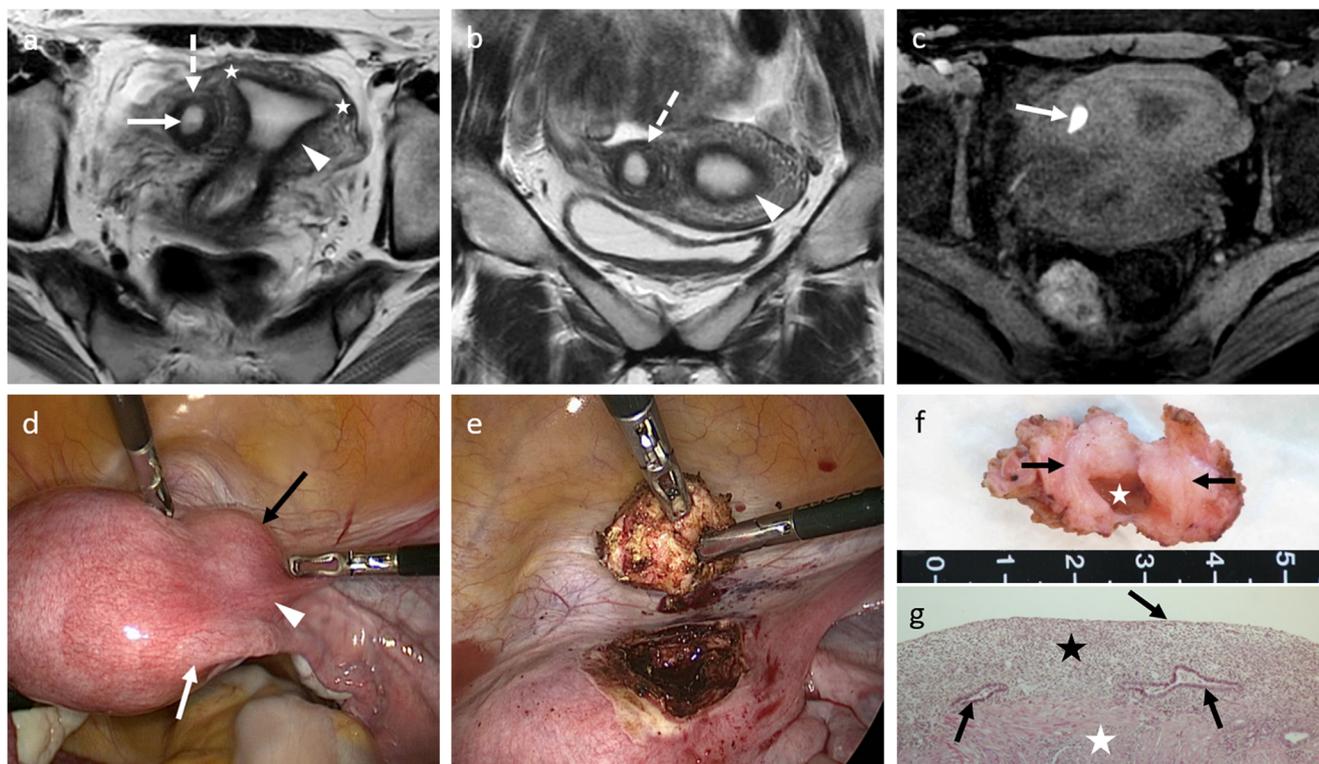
Case 4, a 22-year-old woman with catamenial gradually worsening right-sided pelvic pain. Axial (a) and coronal (b) T2-weighted MRI images show the presence of a focal round cavitated mass of 26-mm width, right-sided in the outer myometrium of the uterus, in subserosal position bulging into the broad ligament (FIGO type 6), with a central fluid level (arrow) and surrounded by a low T2 signal ring (dashed arrows), identical to the junctional zone (arrowheads). Note the normal uterine cavity, with two horns (stars), distinct from the cavitated mass. c Axial T1-weighted MRI image with fat saturation shows a high T1 signal in the central cavity suggesting haemorrhagic content (arrow). d Laparoscopic view shows a uterine right-sided mass
